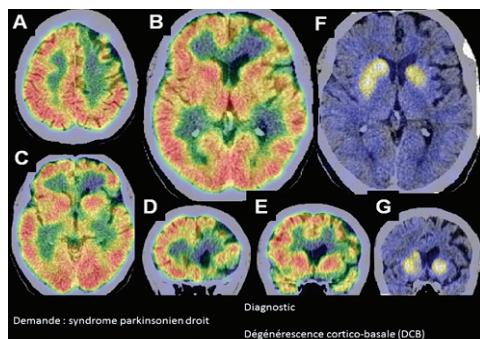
A à E scintigraphie de perfusion cérébrale à l'HMPAO montrant la diminution de la perfusion corticale frontale gauche bien corrélée avec les signes d'atrophie. F et G DaTSCAN™ de ce patient qui présentait un syndrome Parkinsonien droit montrant la diminution de la fixation du putamen. Dégénérescence cortico-basale.
